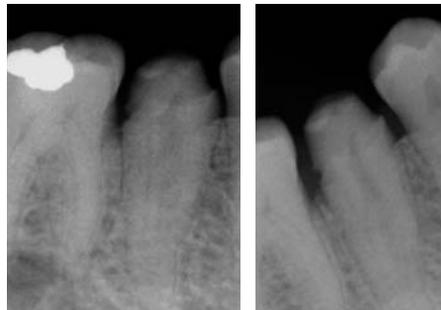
1B: Preoperative radiograph. Note the radiolucent line coronally which disappears abruptly as it progresses down the root. This suggests the presence of a canal bifurcation.
